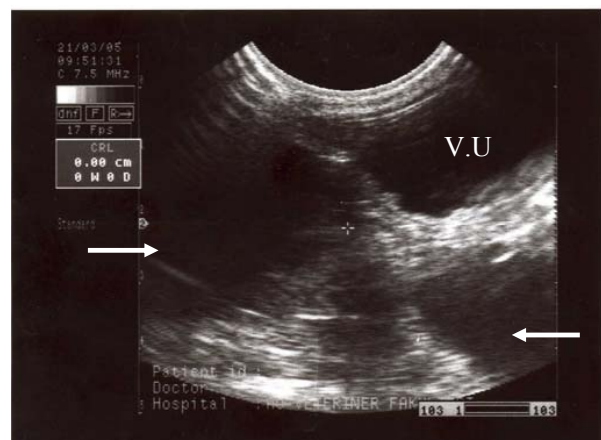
Ultrasonographic view of a large anechoic zone in the uterus
